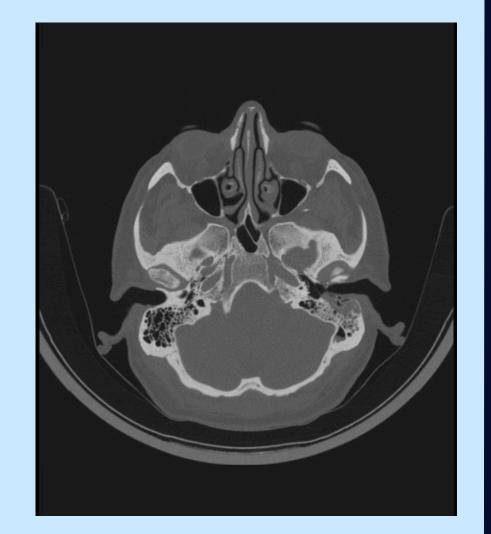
HRCT of temporal bone showing cholesteatoma primarily affecting Left EAC
